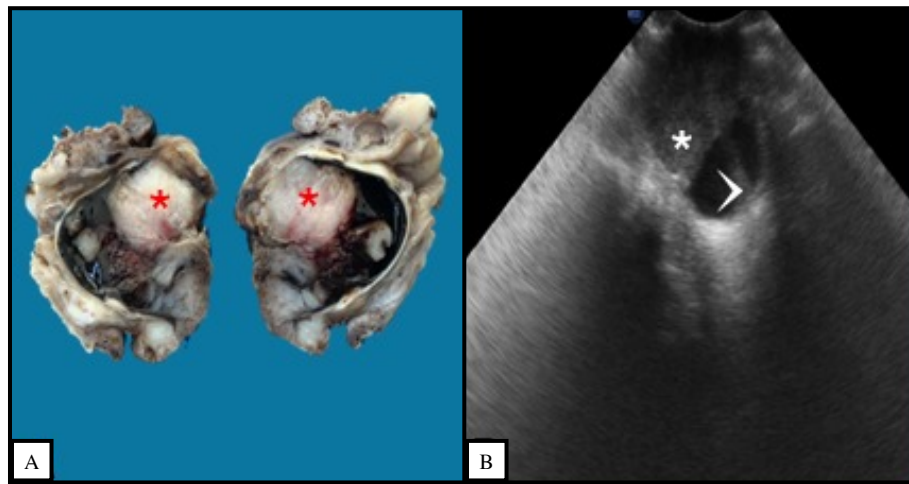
A- Left eye after exenteration and fixation in 10% formalin on a longitudinal section showing a mass (*) involving the ocular bulb. B- Ocular ultrasound image showing a squinted eye with increased axial length due to the presence of a heterogeneous, amorphous mass (*), extending from the cornea to near the retina, which showed multifocal areas of thickening and discrete foci of probable detachment (arrowhead).
